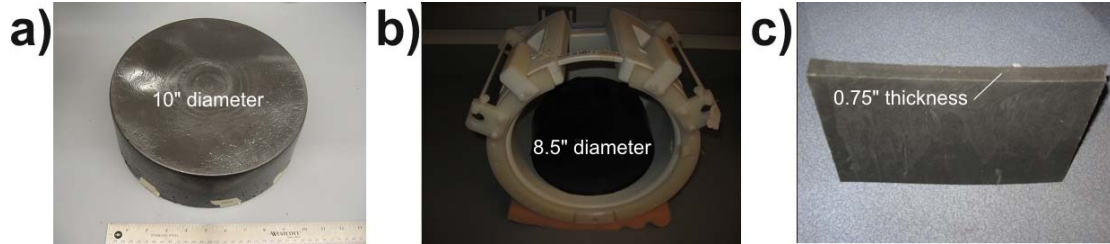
Examples of tissue susceptibility matched PG foam. a) A large PG foam sample (10 in. diameter). b) A 4.5 L sample (8.5 in diameter) PG foam in a Varian 4T head coil. This setup was used for conductivity and heating tests. c) An example of 0.75 in. thick sheets of PG foam that can be used for padding or wrapping patients in an MRI exam.
